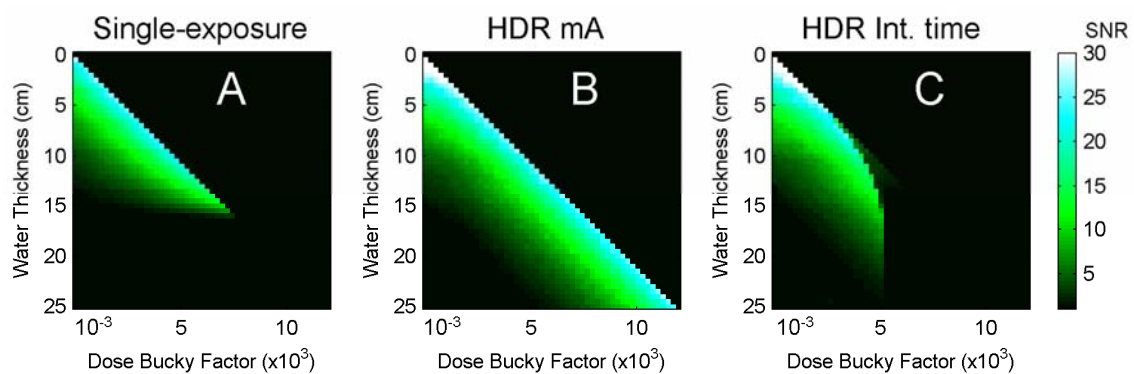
Performance of the HDR method for the extension of detector dynamic range estimated by the SNR of the acquired data for different attenuation values (B, increasing the x-ray source current and C, increasing the image integration time) compared to the SNR obtained by averaging techniques for the same attenuation values (image A). When the attenuation of the x-ray beam is large enough, an insufficient number of photons reach the detector, no information is registered in the image, and the SNR falls to zero owing to the lack of signal. Using the HDR method, the SNR of the image can be maintained almost constant, provided the current span of the x-ray source is large enough.
